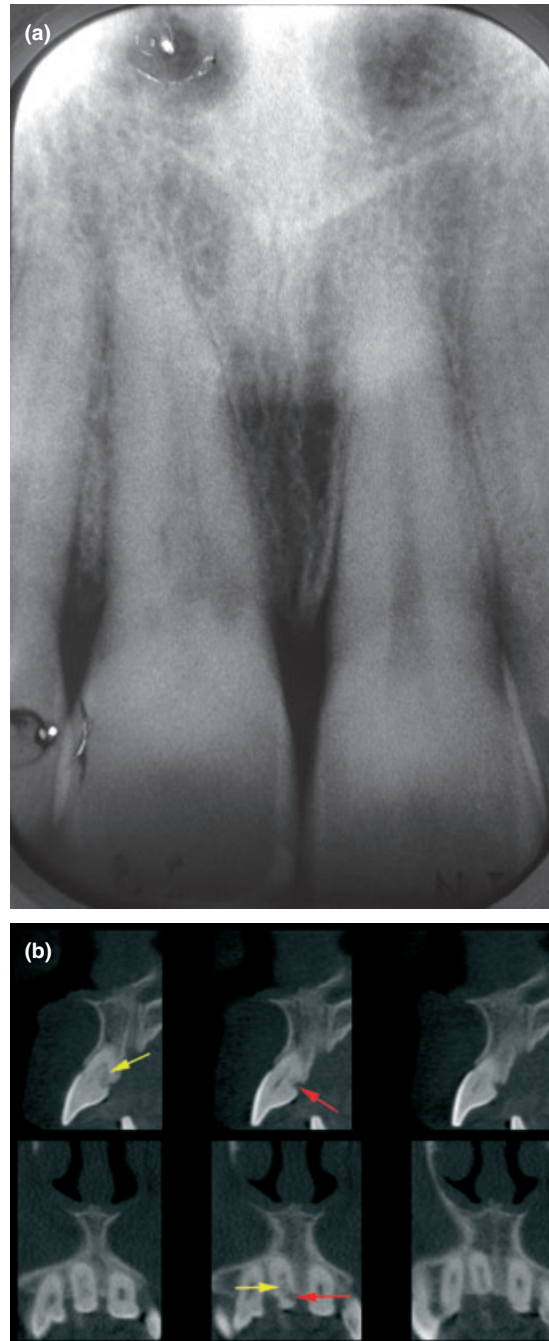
(a) Periapical radiograph reveals external cervical resorption in tooth 11. CBCT images reveal the exact location and dimensions of the resorptive lesion. (b) Sagittal (top) and axial (bottom) slices reveal the true nature of the lesion, the resorptive lesion has two distinct areas. The outer portion (red arrow) has the classical appearance of external cervical resorption, (i.e. radiolucent lesion with irregular borders), and the inner portion (yellow arrow) which has a mottled appearance (which was not completely detectable on the periapical radiographs), suggesting this portion of the lesion contained fibro-osseous tissue.
